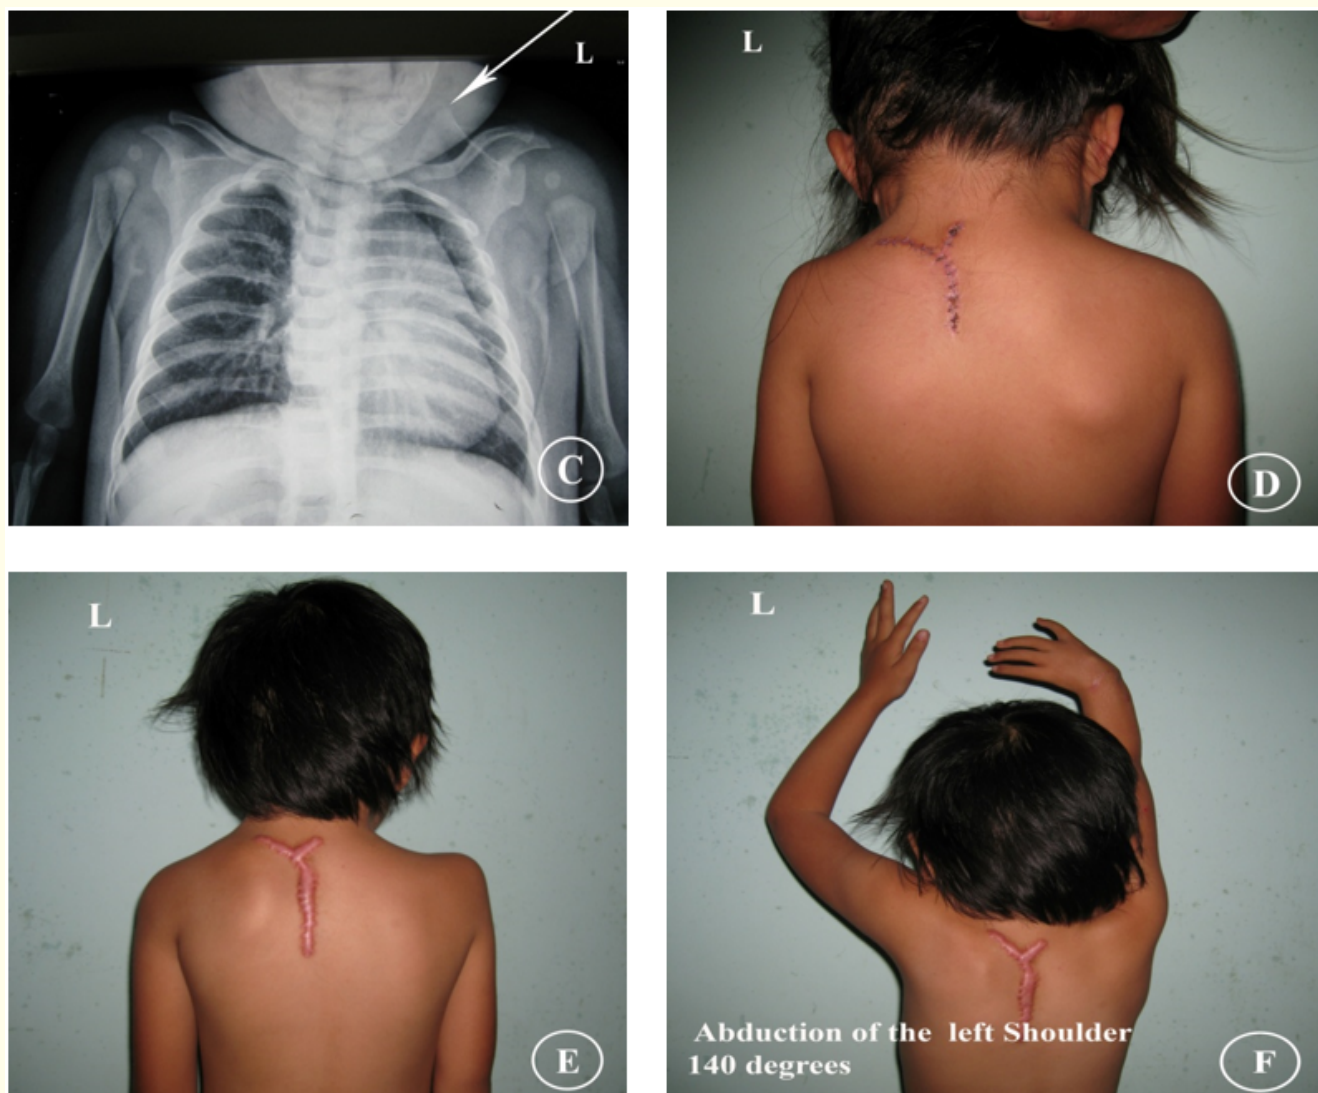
Girl, Age at Operation was 4 years, 6 months. A. Preoperative with Cavendish grade 3; B. Abduction of the Shoulder was 95°; C. Roentgenography shown high left Scapula. D. Postoperative 3 weeks, Cavendish grade 1. - Postoperative 4 years 8 months, E. Cavendish grade 1; F. Abduction of the Shoulder was 140°.
